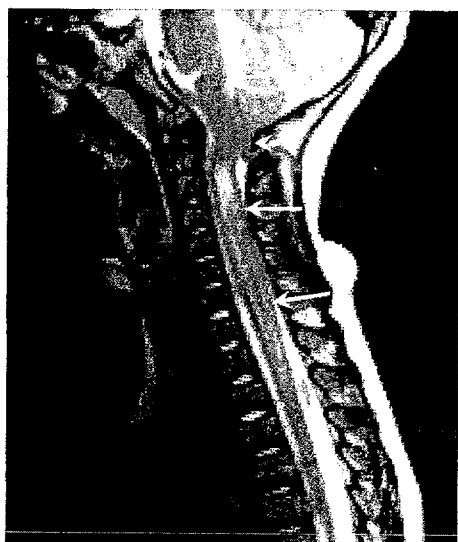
Image obtained from a 3-year-old boy with Chiari I malformation, minor trauma, and subsequent quadriplegia. Sagittal T2 MRI scan shows cerebellar tonsils extending into the upper cervical canal (upper arrowhead) and diffuse high-intensity edema of the cervical spinal cord (lower arrows). No abnormality was present on plain films or CT (SCIWORA).
